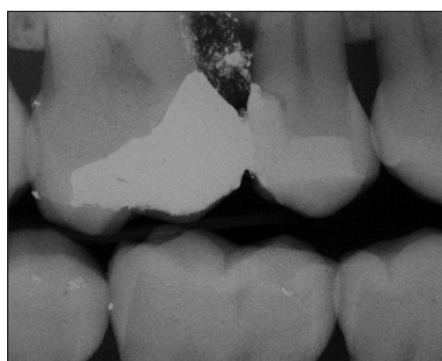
Radiographic image of the corrected restoration. Note the presence of amalgam debris even after copious rinsing.
